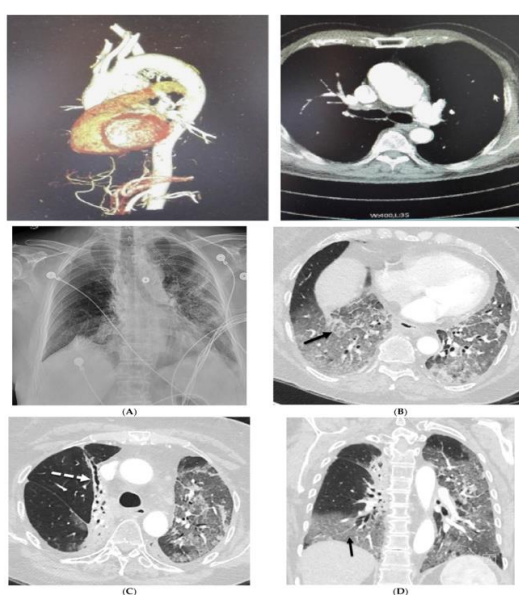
Enhancement of chest CT.
